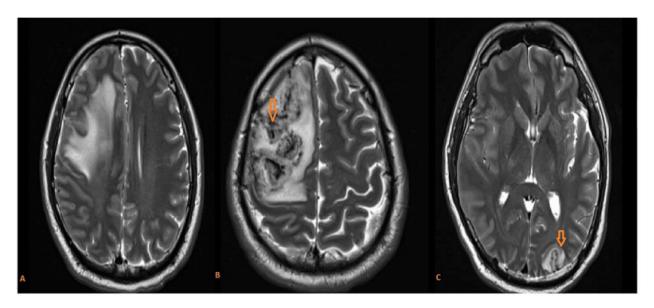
MRI Brain Axial T2-weighted (T2W) imaging (A, B, C)
